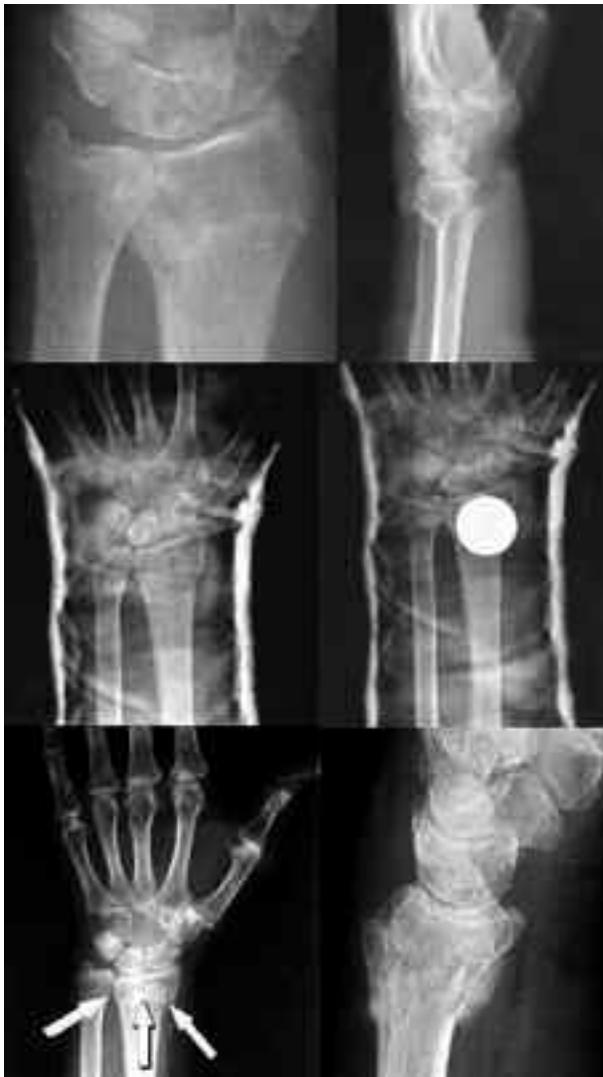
Fracture of the distal epiphysis of the left radius with dorsal dislocation, without metaphyseal fragmentation. X-ray of the fracture after reduction and placement in a plaster cast with and without a magnet and at the removal of the cast with presence of bone callus
